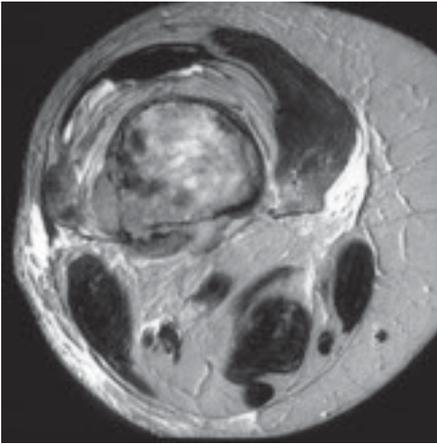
Malignant fibrous histiocytoma of bone. Axial T2-weighted MR image demonstrating an inhomogeneous lesion with cortical destruction and soft tissue extension.
